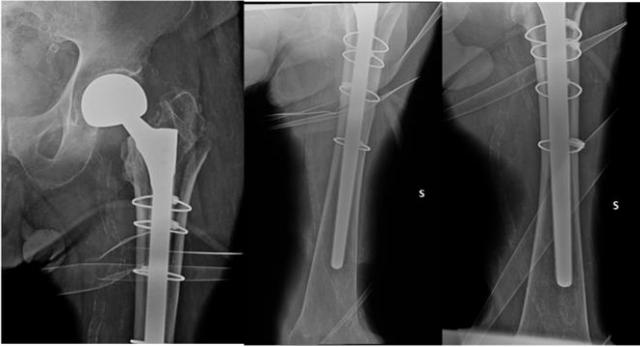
Vancouver B2 fracture: postoperative radiographs showing treatment with revision surgery in association with cerclage wiring.
